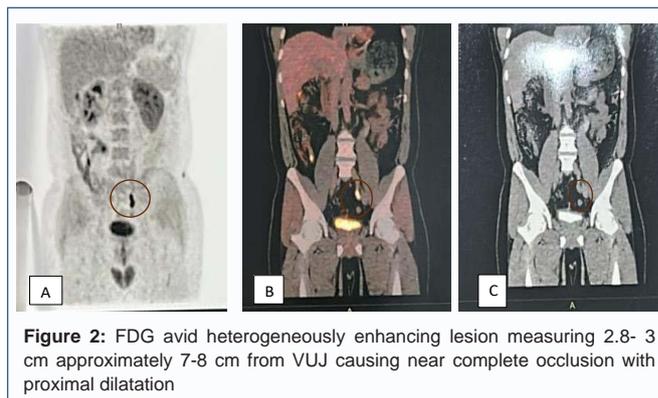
FDG avid heterogeneously enhancing lesion measuring 2.8- 3 cm approximately 7-8 cm from VUJ causing near complete occlusion with proximal dilatation
